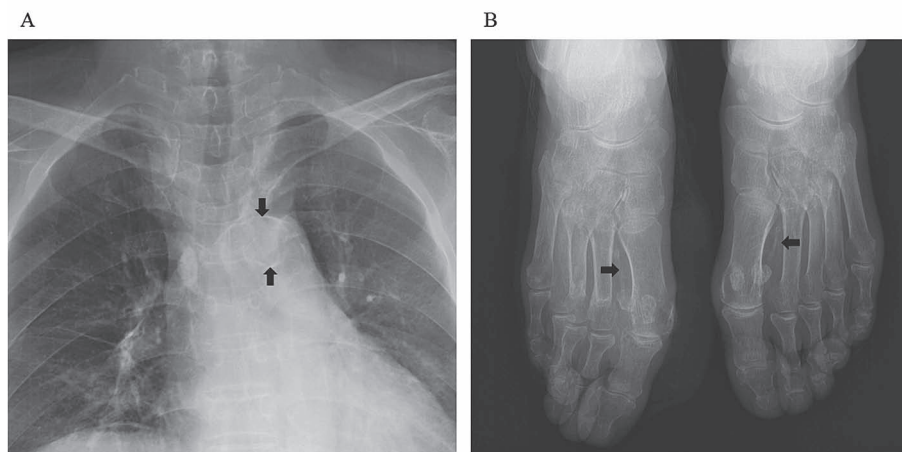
Vascular calcification on plain radiographs of chest and feet.
